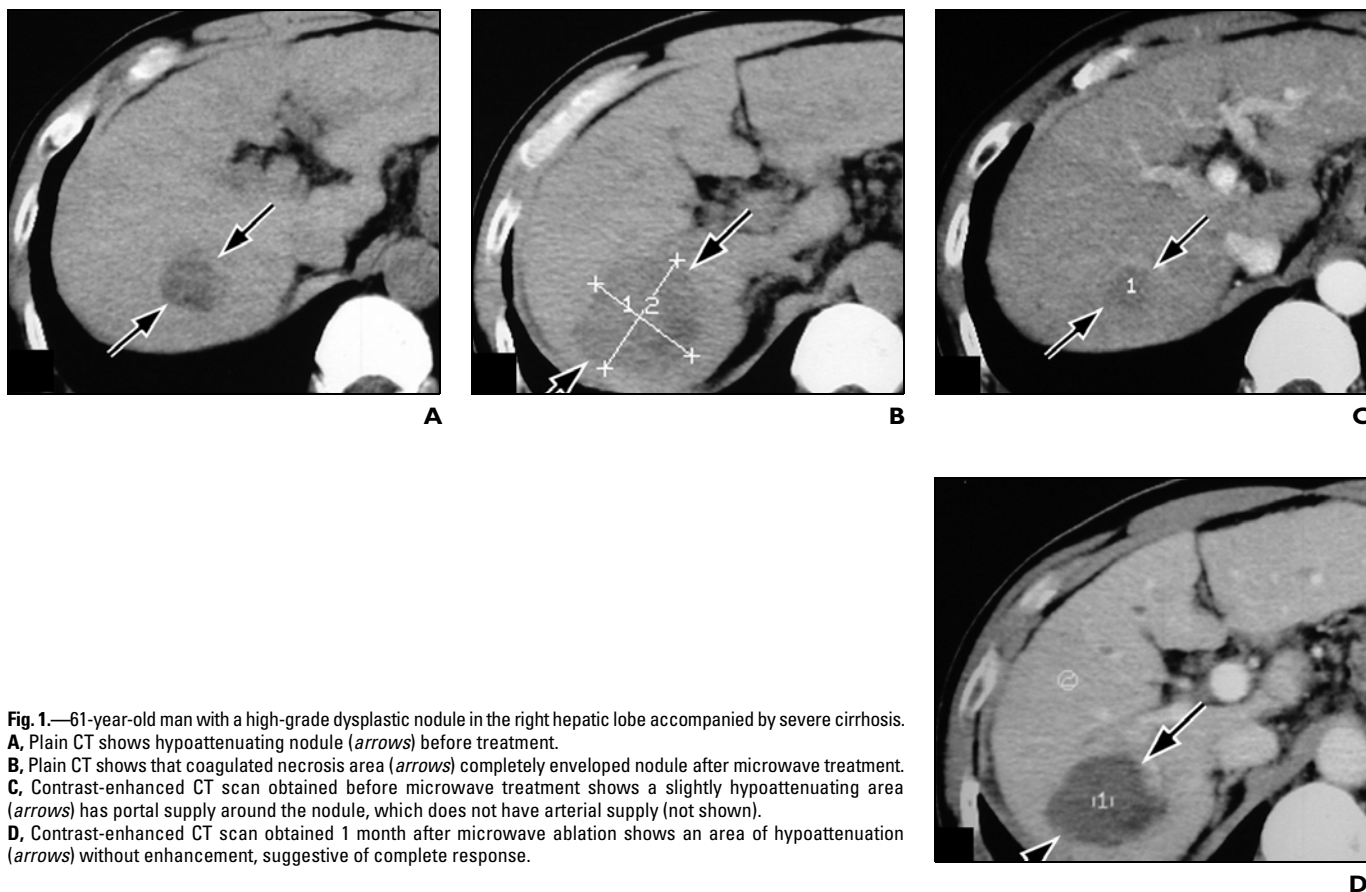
61-year-old man with a high-grade dysplastic nodule in the right hepatic lobe accompanied by severe cirrhosis. A, Plain CT shows hypoattenuating nodule (arrows) before treatment. B, Plain CT shows that coagulated necrosis area (arrows) completely enveloped nodule after microwave treatment. C, Contrast-enhanced CT scan obtained before microwave treatment shows a slightly hypoattenuating area (arrows) has portal supply around the nodule, which does not have arterial supply (not shown). D, Contrast-enhanced CT scan obtained 1 month after microwave ablation shows an area of hypoattenuation (arrows) without enhancement, suggestive of complete response.
